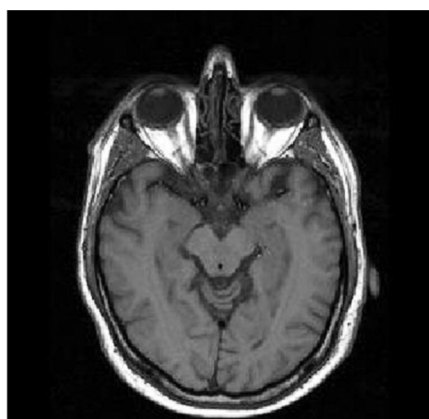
T1 weighted MR image of the brain.
